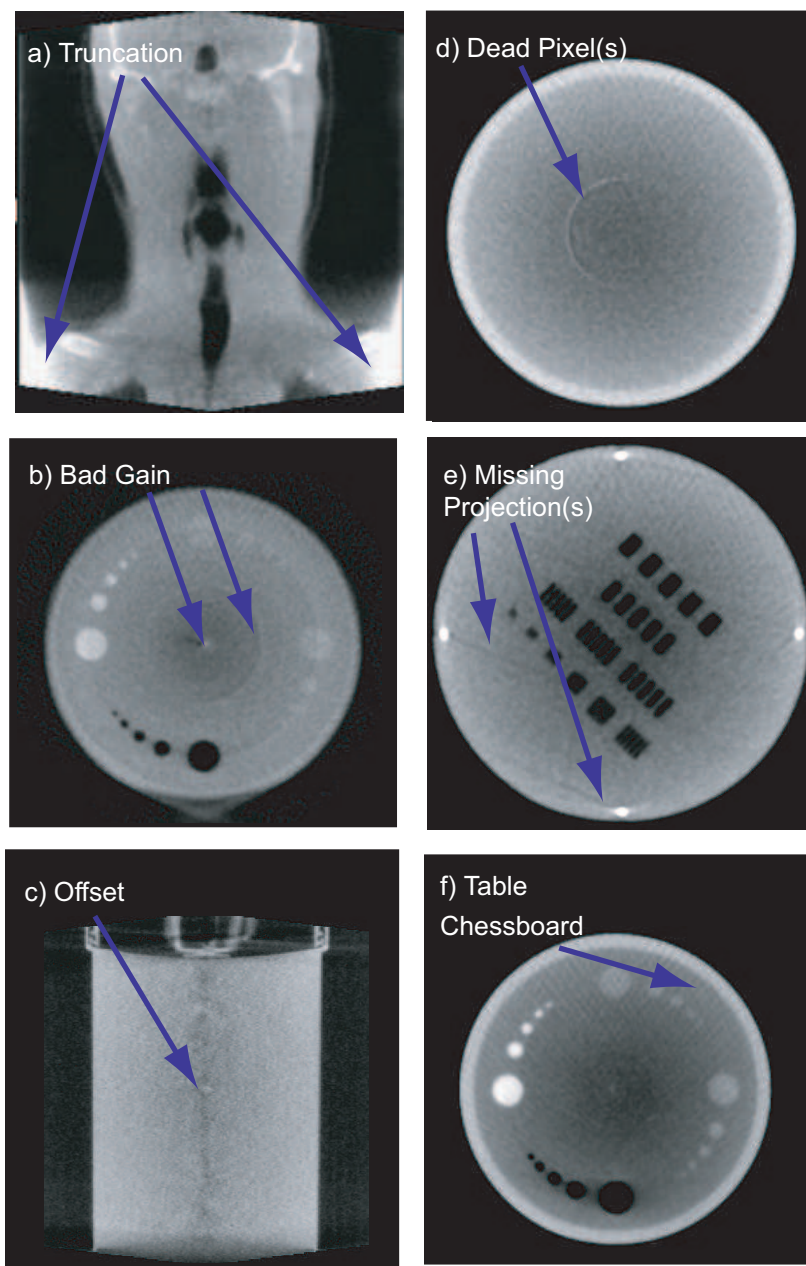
Library of image artifacts possibly occurring with MVCBCT imaging.
